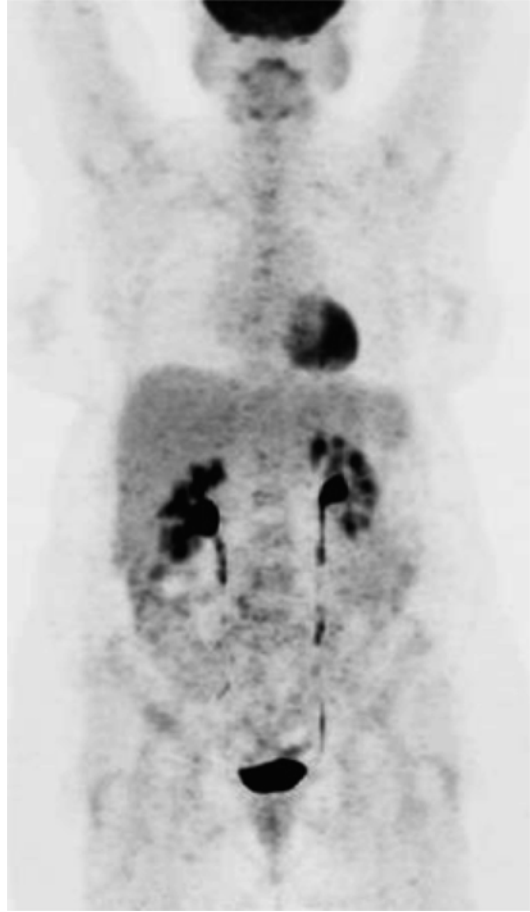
MIP of interim PET/CT. There is almost disappearance of pathologically increased metabolic activity
